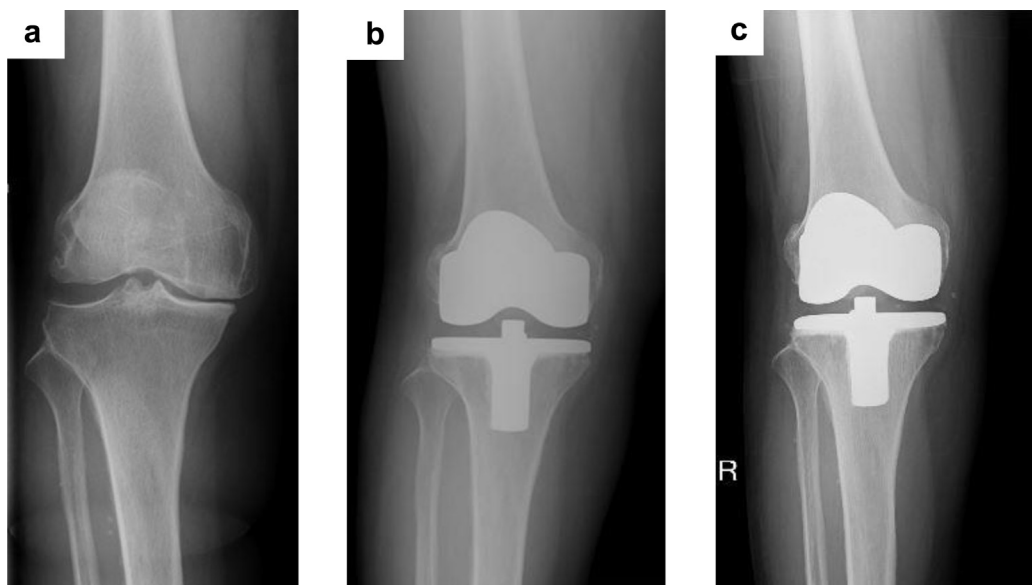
Plain radiographs of the affected knee (a) before TKA, (b) after TKA, and (c) during the occurrence of pseudogout.
